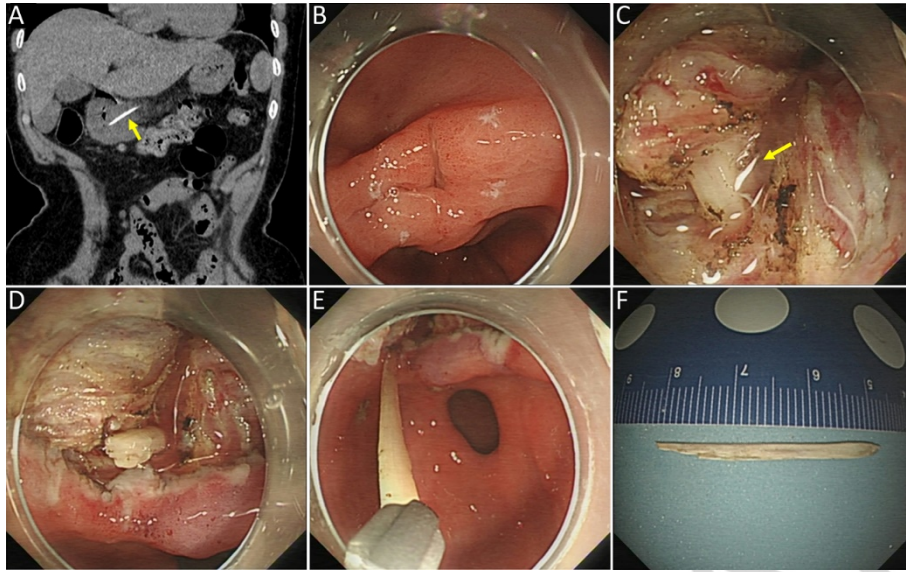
A. Coronal computed tomography image showed an approximately 3-cm linear hyperdense object (yellow arrow) in the gastric antrum. B. Endoscopy revealed a hole-like ulcer at the lesser curvature of the gastric antrum. C. A hard whitish object (yellow arrow) was noted in the submucosal space during the dissection. D. After complete dissection, a bony foreign body (FB) was demonstrated vertically embedded in the muscular tissue. E. The FB was removed with a forceps. F. The extracted FB.
